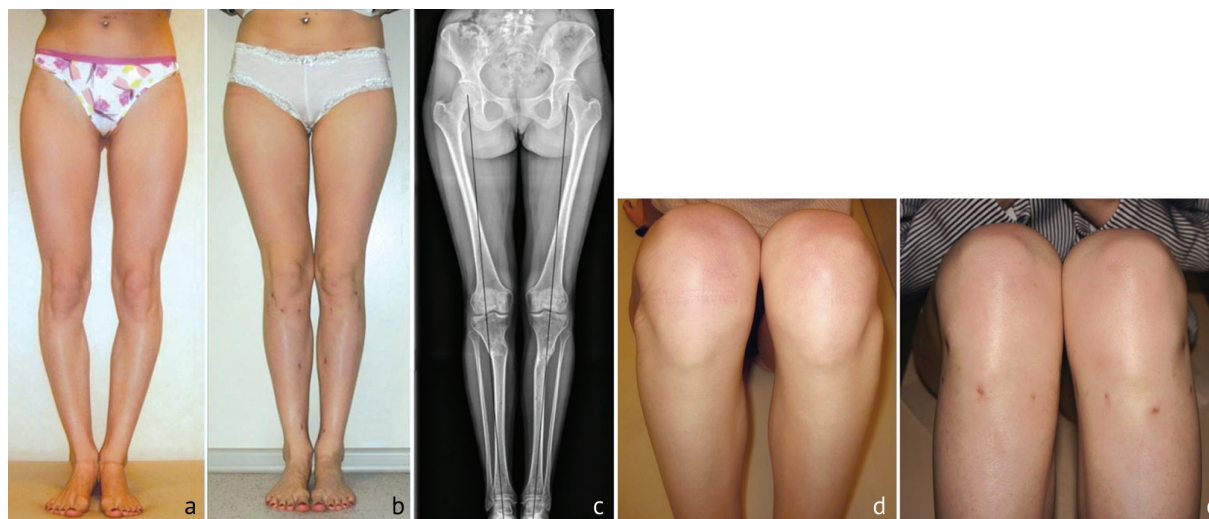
A 28-year-old female patient with varus deformity, subluxation of the fibular heads, external rotation of the right leg: *a* appearance before surgery, there is a fusiform defect of the inner contour, external rotation of the right foot; *b* appearance 8 months after surgery (2.5 months after removing the apparatus); *c* radiographs of the lower extremities one year after surgery; *d* appearance of the knee joints bent before the operation with protruded heads of the fibula; *e* appearance of the knee joints after surgery with an even lateral contour, the heads of the fibula are not visible
